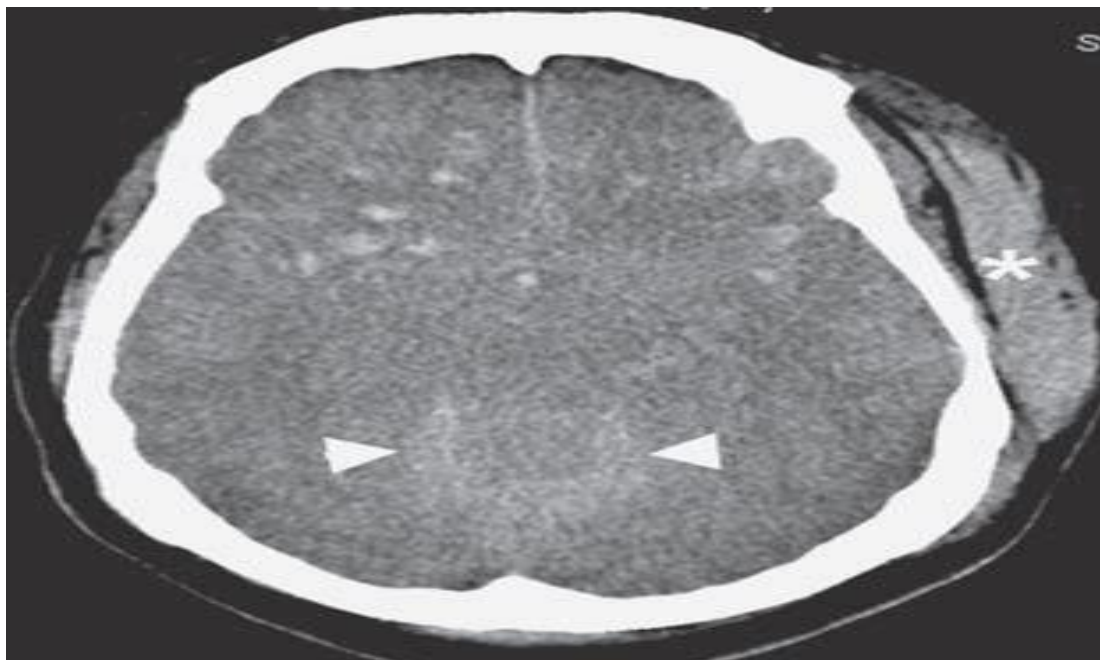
Multi-focal contusions within both frontal lobes, with additional acute Subarachnoid hemorrhage on the tentorium (arrowheads). Marked left fronto-parietal soft tissue swelling(asterisk). (Interpretation of Emergency Head CT Erskine J. et.al 2008).
